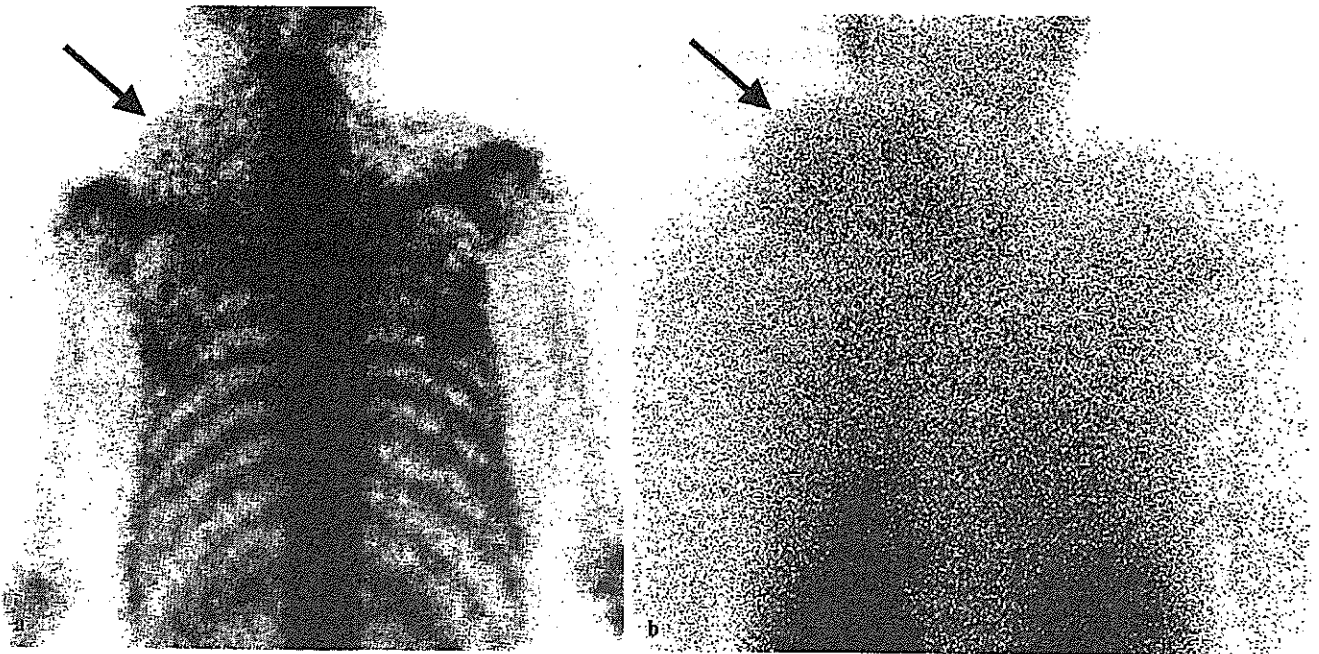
a Posterior view of ^{99m}Tc -HMDP bone scintigraphy demonstrates faint extraskeletal uptake in the mass (arrow). b Posterior view of ^{201}Tl scintigraphy shows homogeneous faint uptake in the mass (arrow)
